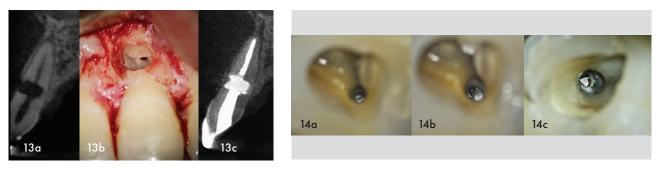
(a) Coronal view of CBCT of a maxillary left central incisor with internal resorption communicating towards the external root surface; (b) lesion was debrided under magnification (15X); (c) Coronal view of CBCT one year after treatment with MTA.
